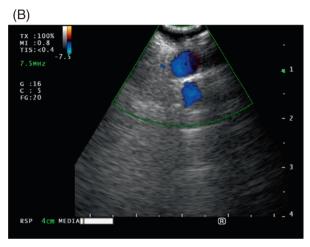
(A) Narrow band imaging of the raised vascular lesion at the left upper lobe. (B) Convex probe EBUS image with Doppler shows the presence of a submucosal vessel. EBUS, endobronchial ultrasound.
